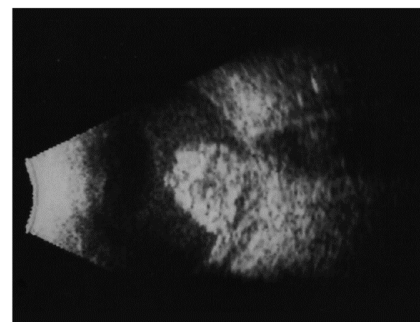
A+B-scan ultrasonography showed vitreous hemorrhage.
